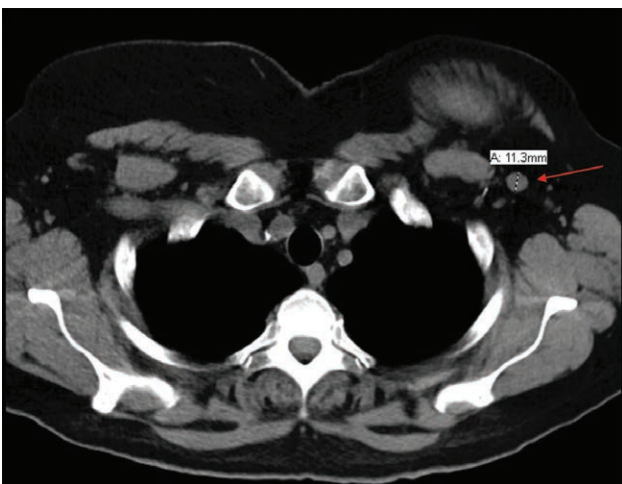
CT chest scan completed in May 2019 showing an enlarged left axillary lymph node.
